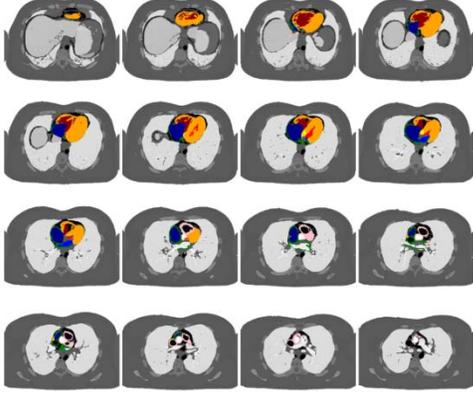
Segmented CT images of the heart regions, lungs and torso.
